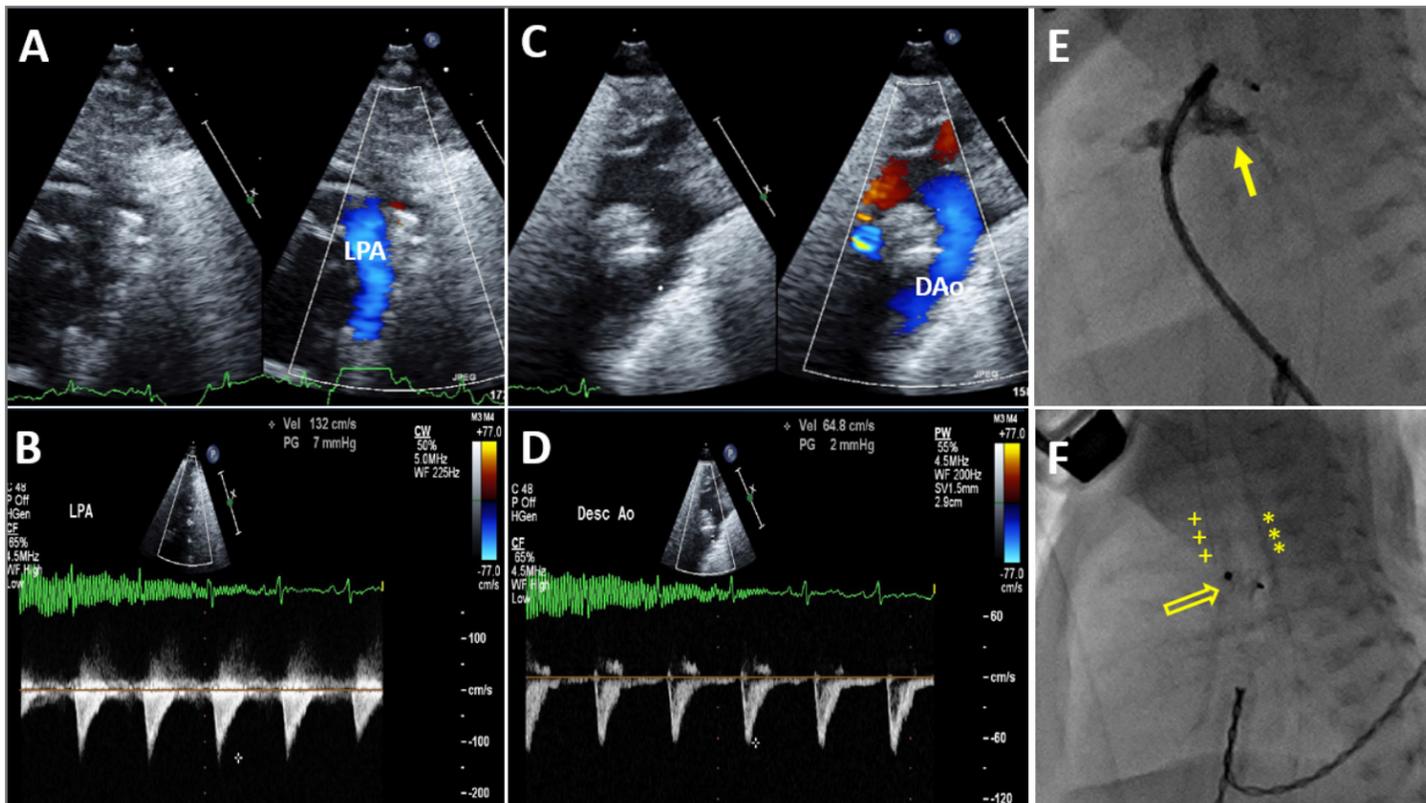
Echocardiographic and angiographic assessment of device position prior to release. Left pulmonary artery appearance and flow are carefully evaluated using a combination of TTE (A-D) and angiography (closed arrow in E) prior to device release. If there is a suspicion of LPA stenosis secondary to device size or position, the device is recaptured and repositioned or replaced with a different size. The descending aorta (C&D) is carefully evaluated by 2D imaging, color and spectral Doppler, and the flow pattern and velocities compared to the baseline measurements. This is a critical evaluation as in preterm PDA closure there is no aortic catheter placed to perform angiograms or measure pressures. Should aortic obstruction be caused by the device it should be repositioned or removed. (F) Fluoroscopy following device release shows a well-positioned device (open arrow) located between the previously noted temperature probe (*) and PICC line (++++) landmarks.
